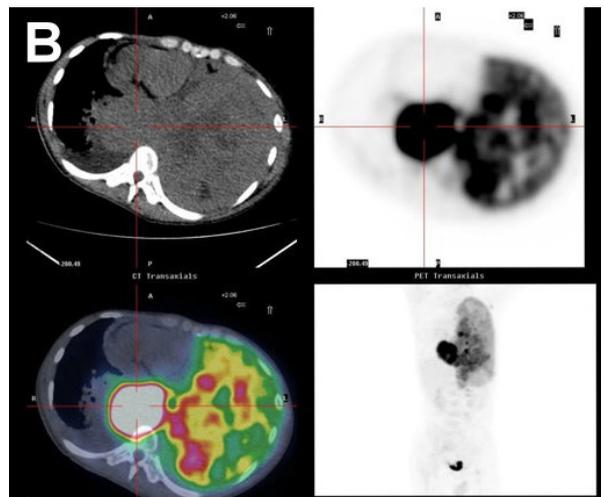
High FDG (SUVm 18) uptake in the mass, which was located in the posterior inferior mediastinum.
